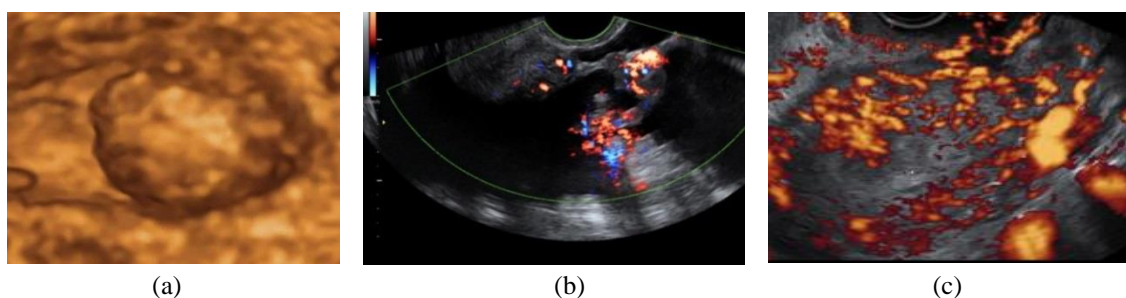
Different US images (a) 3D scan of Endometrioma/benign tumour (b) 2D colour Doppler of metastatic malignant, (c) 2D power Doppler for highly vascularized malignant tumour.
